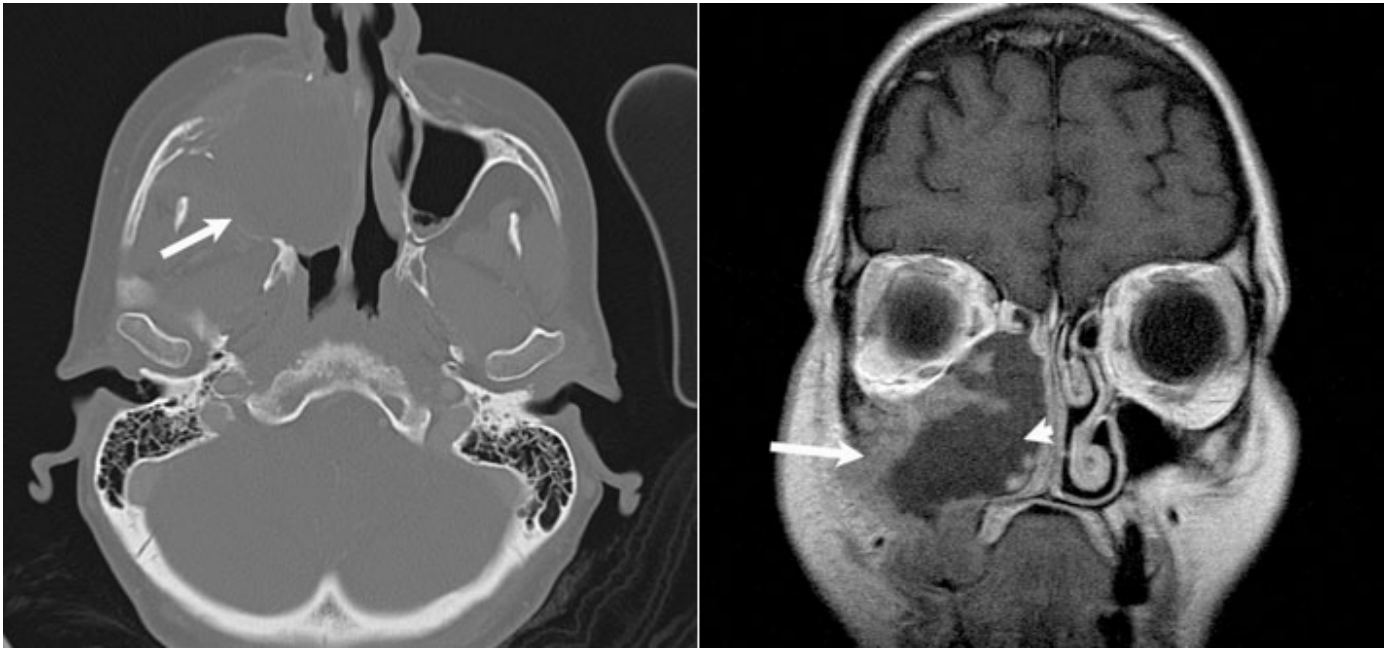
(A) CT of a patient with maxillary sinus cancer demonstrates bony destruction, (arrow) a hallmark of malignancy. (B) MRI in the same patient more accurately distinguishes between the intermediately enhancing tumor (long arrow) lining the maxillary sinus and the non-enhancing secretions (short arrow) filling the maxillary sinus.
